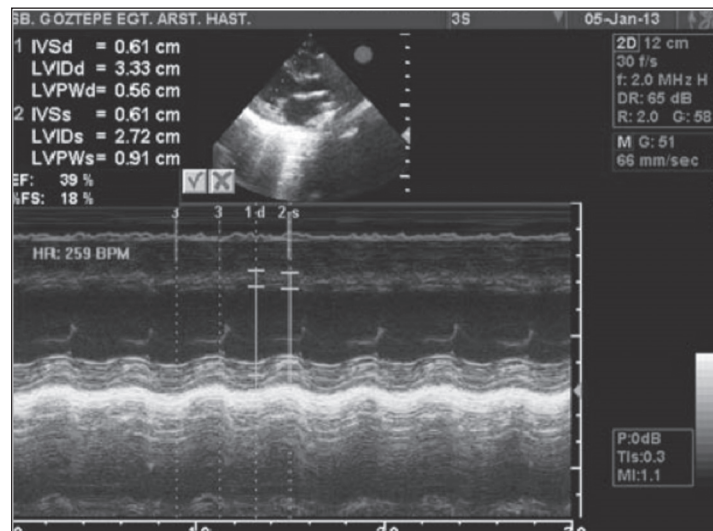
The M Mod Echocardiogram show systolic dysfunction during the last infection period.
